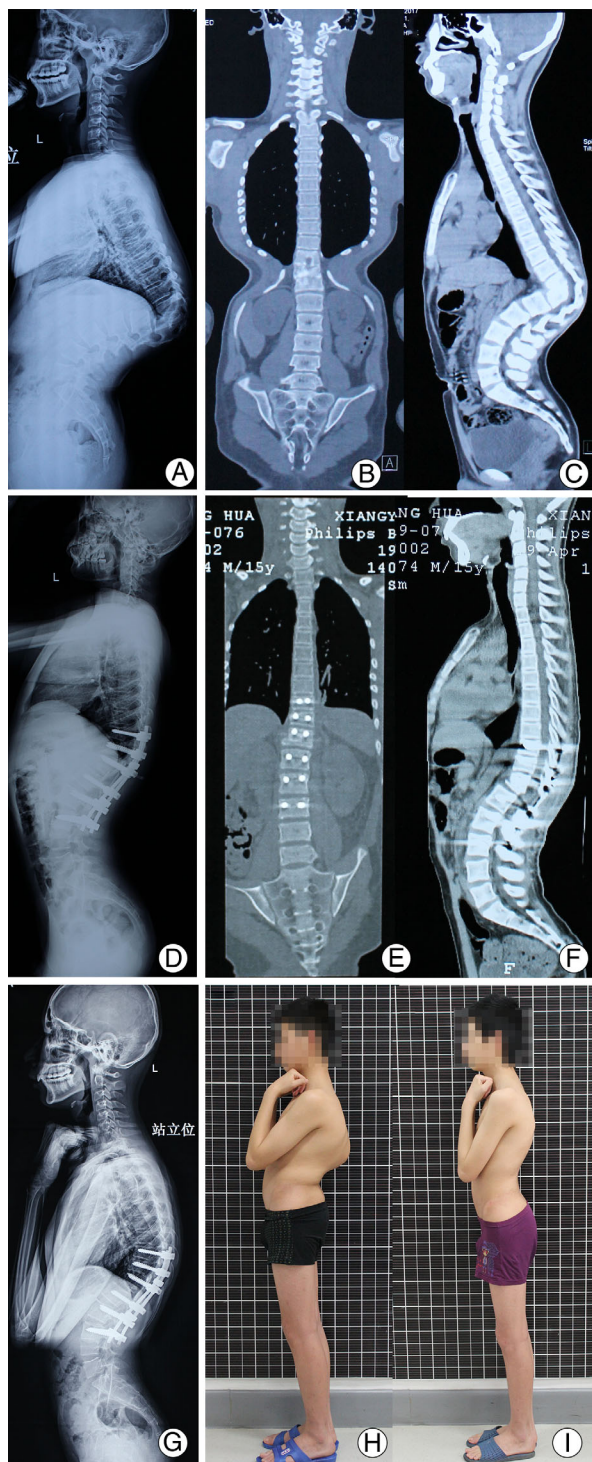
A 10–20-year-old case with T₉₋₁₁ congenital spinal angular kyphosis. (A–C) Preoperative lateral X-ray and 3D CT scan showed a T₉₋₁₁ congenital kyphosis, with a deformity angle of 110.2°. (D–F) Postoperative lateral X-ray and 3D CT scan showed DCVO at T₉₋₁₁ complex, with a deformity angle of 23.1°. (G) Latest follow-up X-ray showed a deformity angle of 21.6°. (H, I) Preoperative and last follow-up clinical photos.
